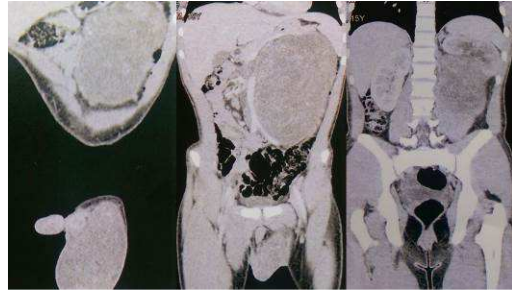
Image of preoperative CT scan of the abdomen and pelvis – testicular and abdominal tumour
